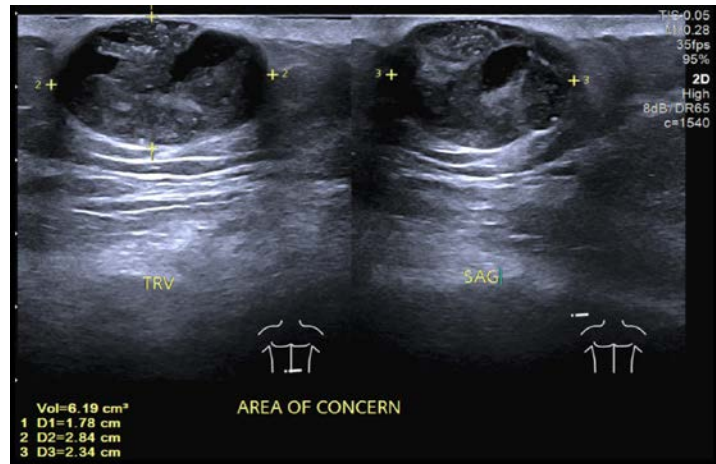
1.78x2.84x2.34 cm y ultrasound
